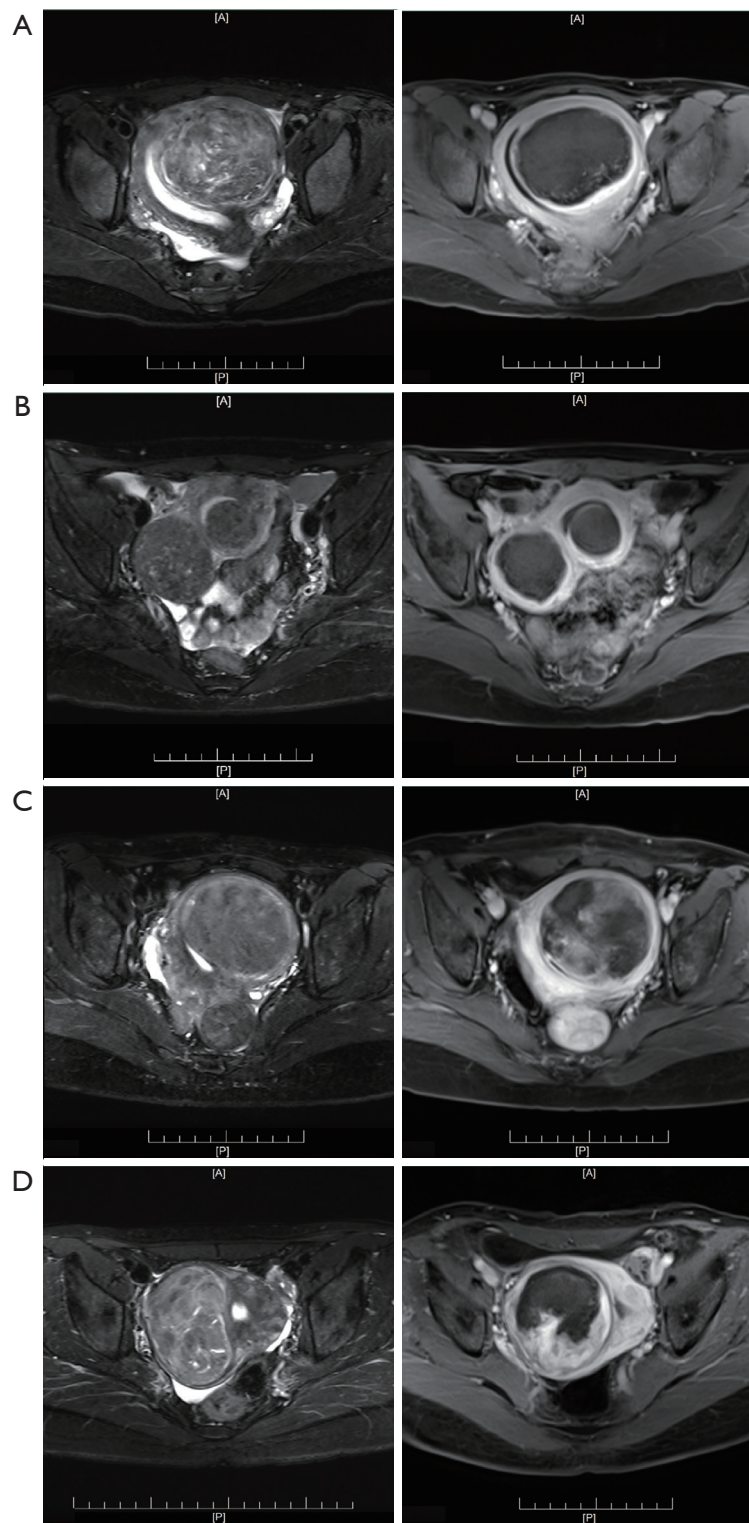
The ablation effect of different types of uterine fibroids. The NPVR $\geq 80\%$ (A,B) and NPVR $< 80\%$ (C,D): an intramural fibroid on the left lateral wall with T2WI hybrid intensity (A); a submucosal and a subserosal fibroid on the right lateral wall with T2WI hypointensity (B); an intramural fibroid with T2-weighted imaging isointensity (C) and an intramural fibroid with T2WI hybrid intensity (D). The minimum scale in these pictures is 10 mm. NPVR, non-perfused volume ratio; T2WI, T2-weighted imaging.
